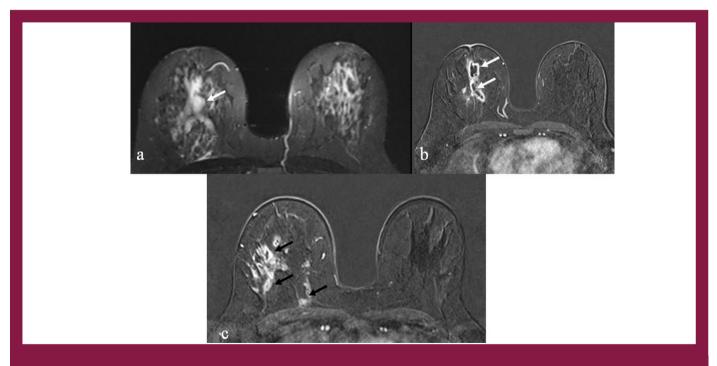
In the dynamic contrast-enhanced MRI examination of a 38-year-old female patient diagnosed with IGM, macro (white arrow) and microabscess foci (black arrow) are observed in the nonmassive enhancement area in the T2W fat-suppressed series (a) and postcontrast dynamic series (b, c)
